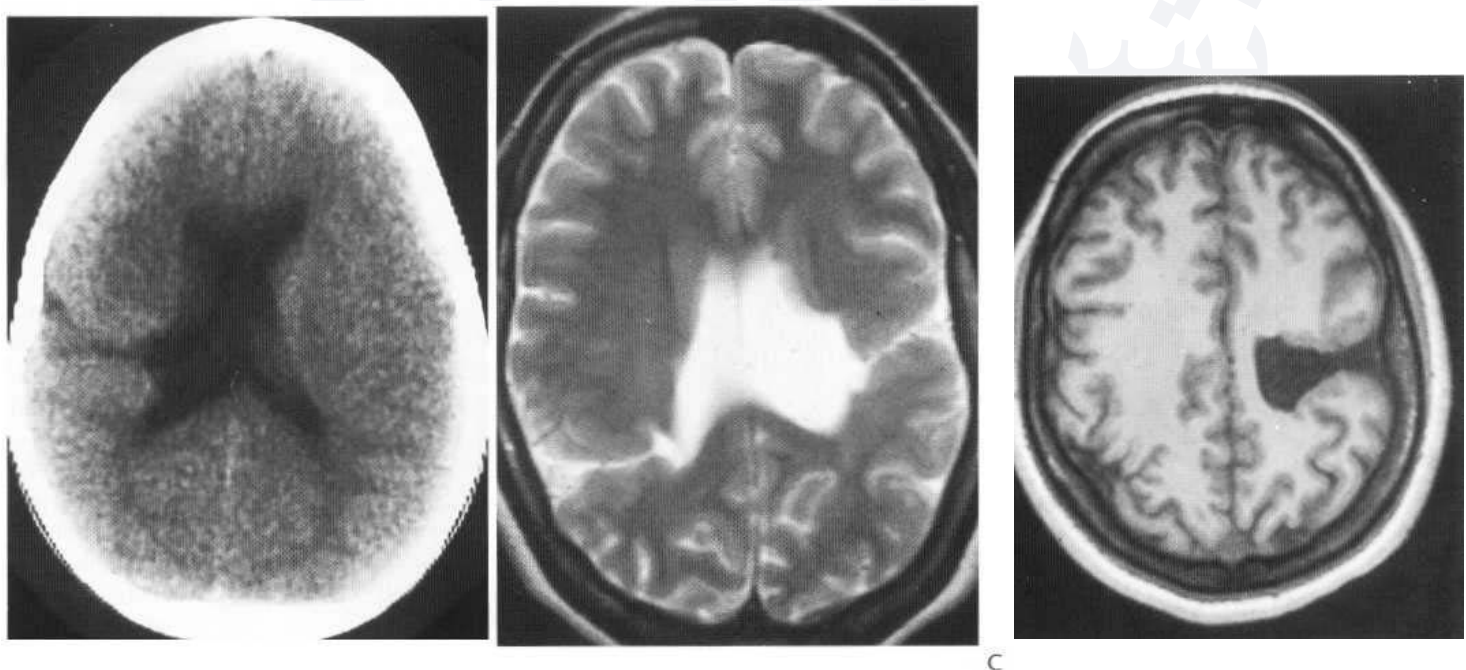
(A) CT shows minor degree of schizencephaly presenting as lateral slit lined by cortex. Axial T₂-weighted image (B) of a patient with bilateral schizencephaly. The clefts radiate out from the lateral ventricles to the surface of the hemispheres and are lined by grey matter. The cleft on the right is closed-lipped whereas the one on the left is open-lipped and this is evident on the more superior axial T₂-weighted image (C).
